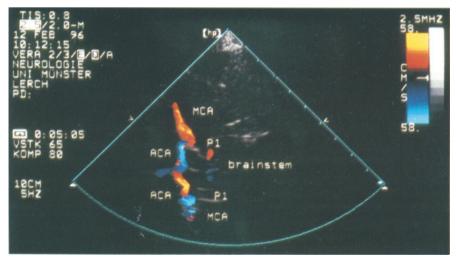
Color-coded Duplex sonography of the circle of Willis
